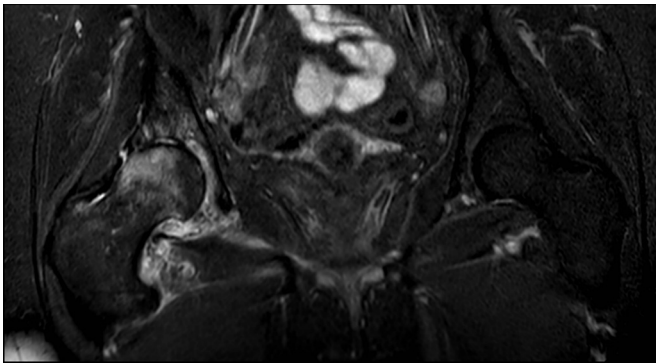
MRI Coronal cut on the pelvis.
